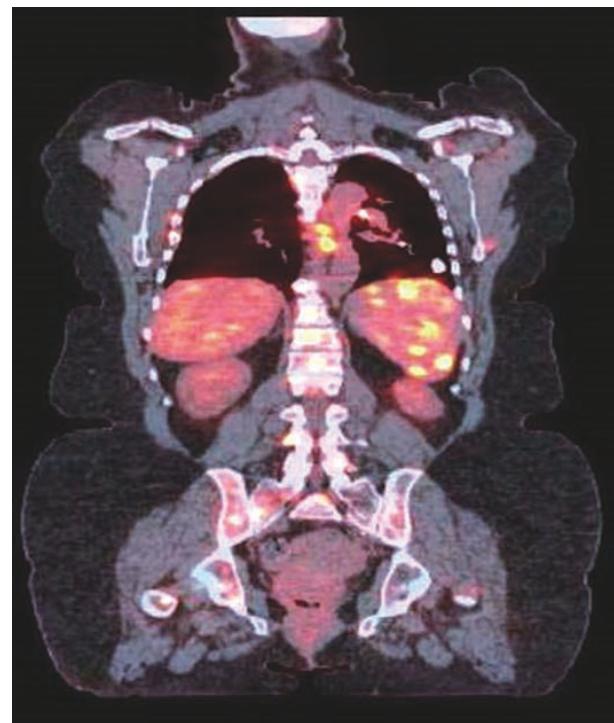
Positron emission tomography and CT scan merged, demonstrating increased activity in the spleen, ribs, and spine of a patient with sarcoidosis.
